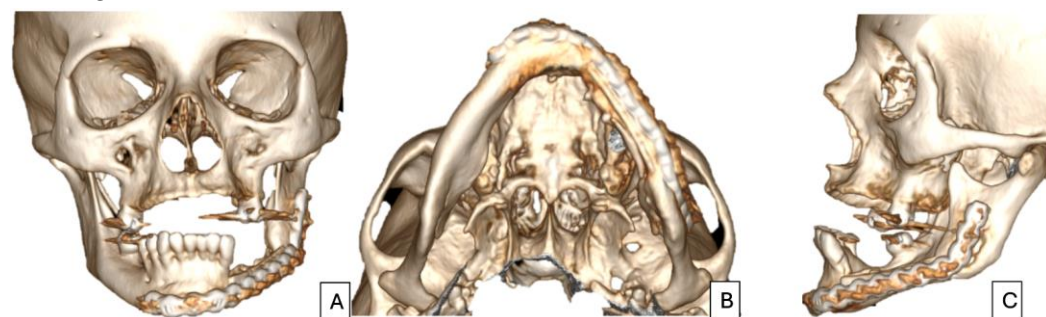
A, B, and C. 3D reconstruction of the postoperative CT scan at nine months, showing maintenance of bone volume and contour.
